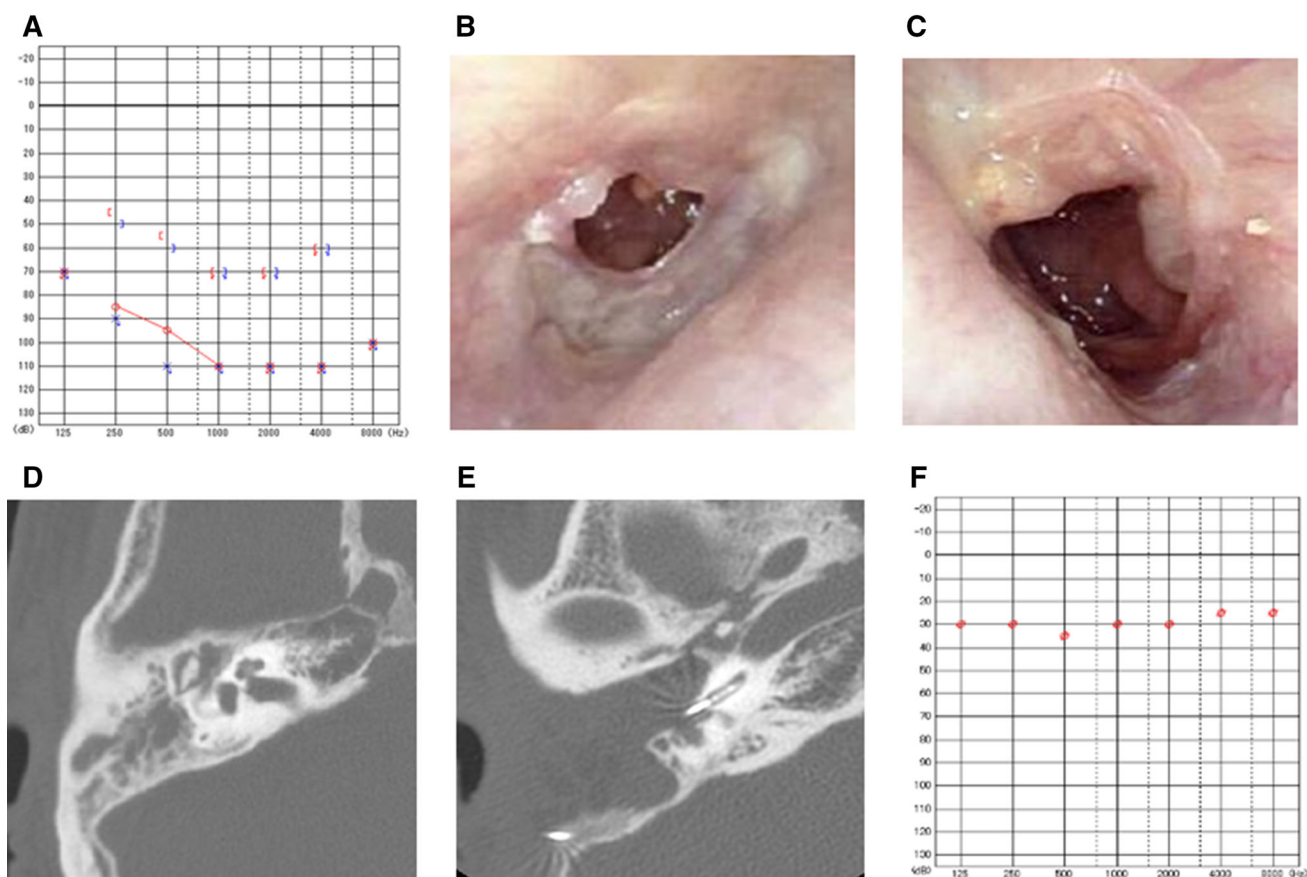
Clinical findings of Case 1. a Pure tone audiogram before surgery, b endoscopic view of right eardrum, c left eardrum, d CT scan before surgery, e CT imaging after surgery, and f hearing threshold result after surgery
